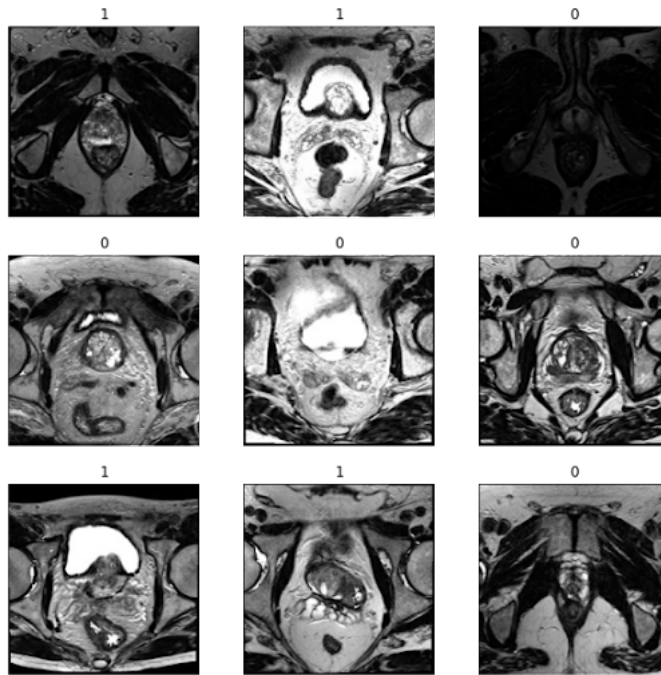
Labelled MRI dataset after Preprocessing.
